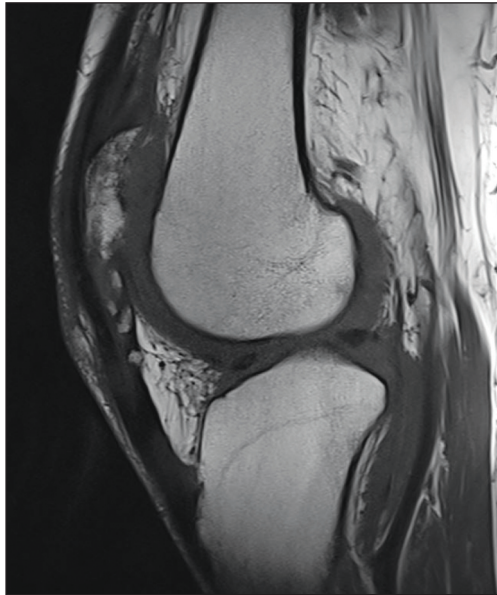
Magnetic resonance imaging of right knee showing calcification of the patellar tendon
